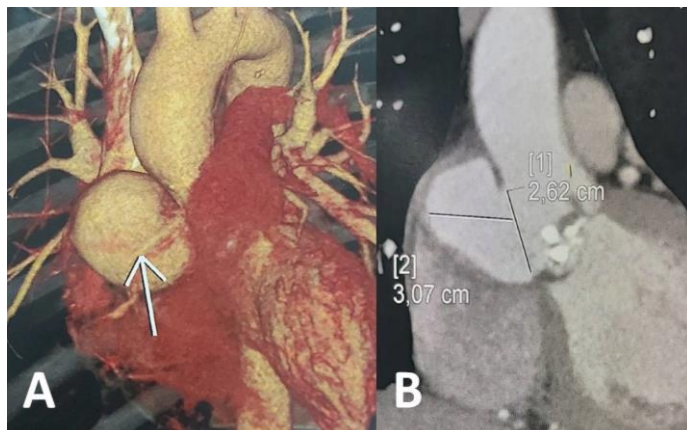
Angio CT scan with 3D reconstruction shown the false aneurysm with right coronary artery compression (White arrow)
